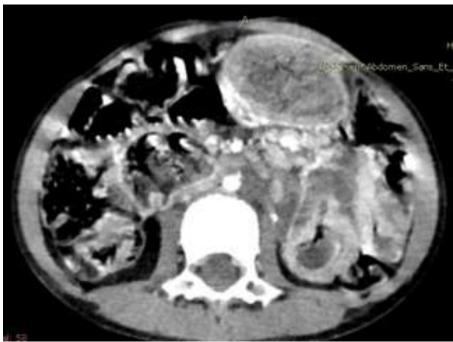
CT scan showing an intragastric trichobezoar with duodeno-jenunal and presence of an invagination bladder on the left flank.
